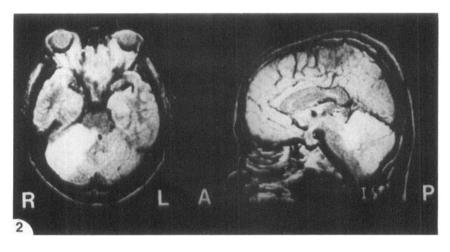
The magnetic resonance imaging of case 2 shows a high intensity area in the right cerebellar hemisphere, the dorsal pontine region, and the superior and middle cerebellar peduncle.
